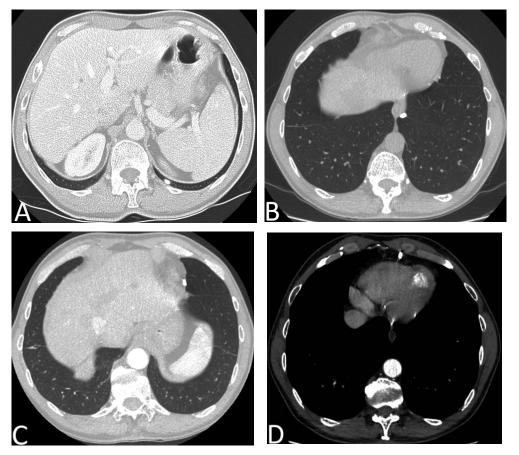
Axial chest CT images (A through C – lung windows and D – mediastinal window) over 18 years of follow-up show an approximately 8 mm thoracolith initially located at the posterior aspect of the left lower lobe/costophrenic sulcus (A) and subsequently migrating to the left posterior aspect of the distal esophagus (B), along the left heart (C), and along the anterior aspect of the heart (D) indicating mobility and diagnostic of a thoracolith, rather than osteosarcoma metastasis.
